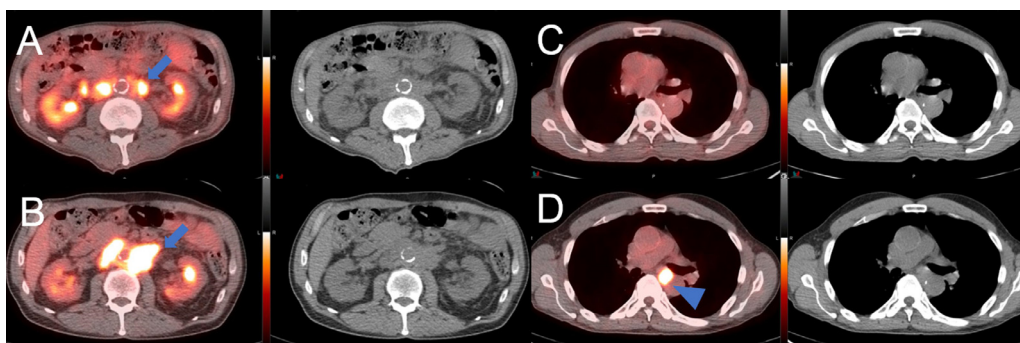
A 71-year-old man with history of poorly-differentiated urothelial carcinoma of the bladder had undergone cystoprostatectomy and pelvic nodal dissection with the creation of an ileal conduit. Five years later, while on immunotherapy with atezolizumab, PET/neCT shows several FDG avid paraaortic nodes, with the index lesion measuring 1.3×1.5 cm with max. SUV 6.3 (A, axial images; arrow), most consistent with disease recurrence. Follow-up PET/neCT performed 8 months later, while on therapy with carboplatin and gemcitabine, shows interval increase in size and FDG avidity of the paraaortic nodes (B, axial images; arrow) and a new FDG avid subcarinal node, 1.2×1.5 cm with max. SUV 6.3 (D, axial images; arrowhead) was not present on the prior exam (C, axial images). Findings are most consistent with disease progression. The patient died four months later.
